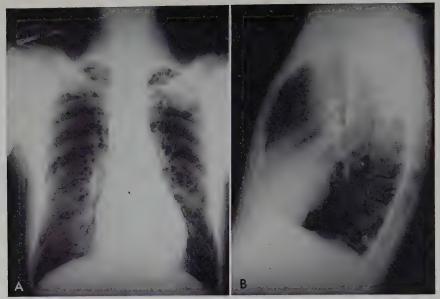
(Case I). Anteroposterior and lateral roentgenograms of the chest demonstrate the lesion in the apical posterior segment of the left upper lobe.
